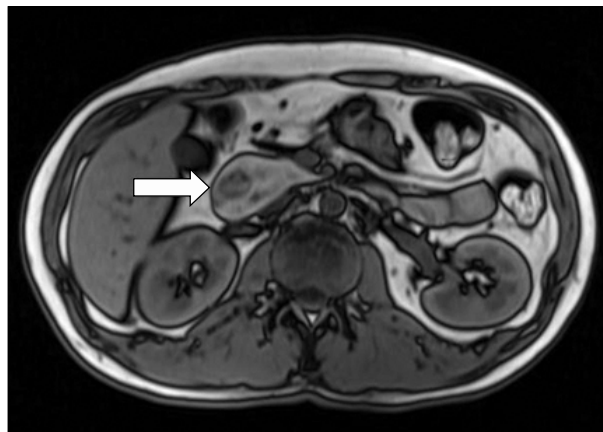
Magnetic resonance image shows circumferential pancreas around the second portion of the duodenum with luminal narrowing.
